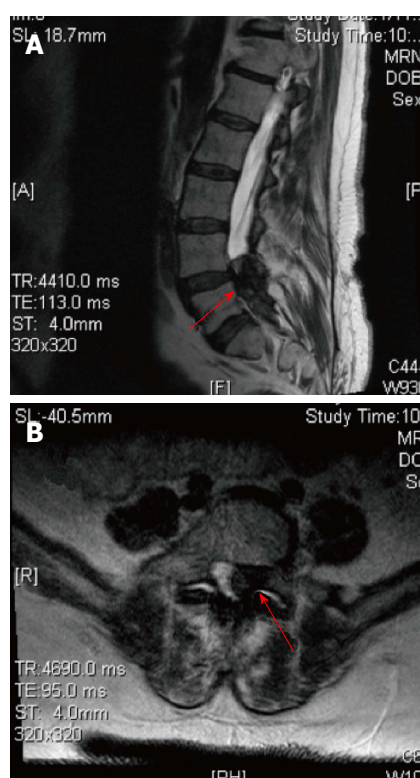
T2 weighted magnetic resonance imaging scan mid sagittal (A) and axial (B) showed intraspinal extradural hypodense lesion causing spinal canal stenosis at L4-S1.
